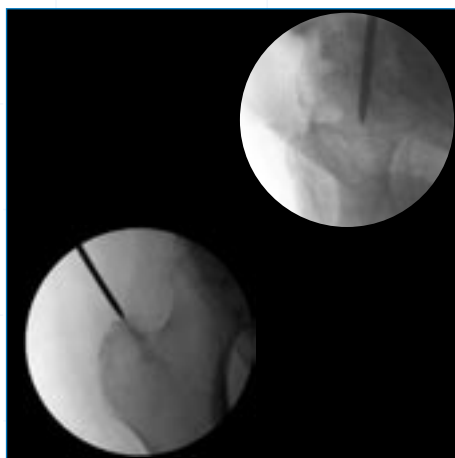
Confirm correct entry location and guide pin placement radiographically with AP and lateral views. The guide pin should be in line with the femoral canal in the lateral view and angled approximately 6 degrees in the AP view. Care should be taken to ensure that the guide pin and channel reamer do not migrate laterally, causing varus malalignment (Fig. 6).
